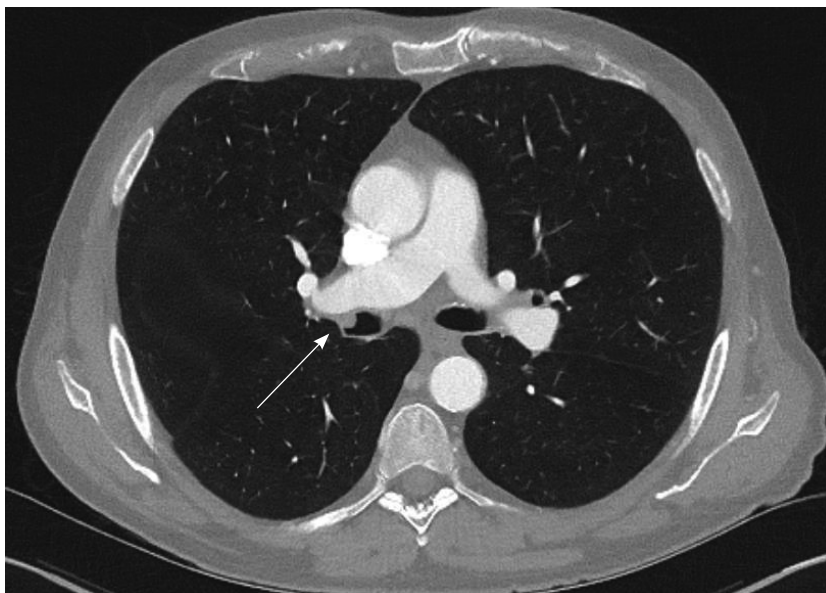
Computed tomography scan of lesion at the bronchus intermedius.
